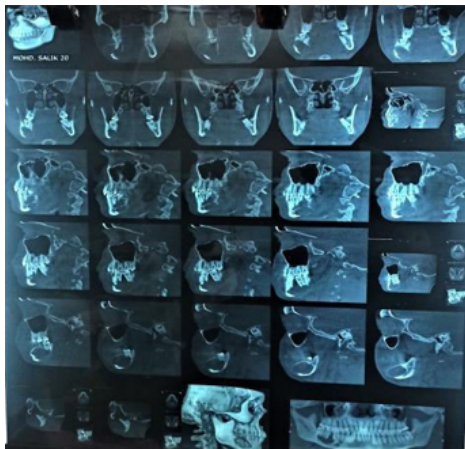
CBCT scan reveals single unilateral, multilocular, well defined radiolucency surrounded by well cortical border in the right mandible posterior region
